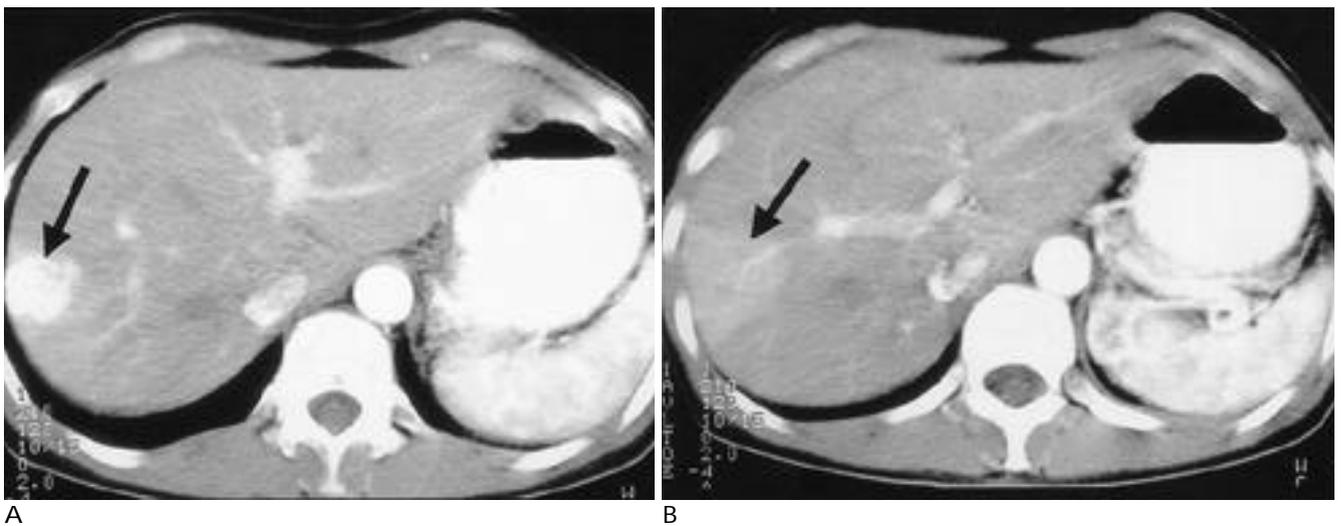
CT scan obtained in a 44-year-old woman with hemangioma.
